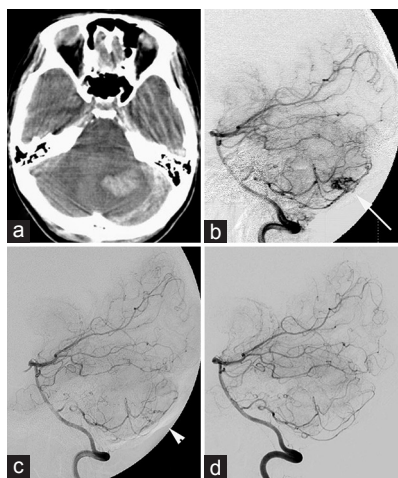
(a) CT scan at initial onset demonstrating left cerebellar hemorrhage with subarachnoid hemorrhage. (b) Left vertebral angiogram before first gamma knife radiosurgery showing a left cerebellar hemispheric AVM supplied by posterior inferior cerebellar artery (arrow). (c) Left vertebral angiogram at 3 years after first radiosurgery revealing residual nidus in the left cerebellar hemisphere (arrowhead). (d) Left vertebral angiogram obtained at 5 years after the second radiosurgery revealing no residual AVM nidus
